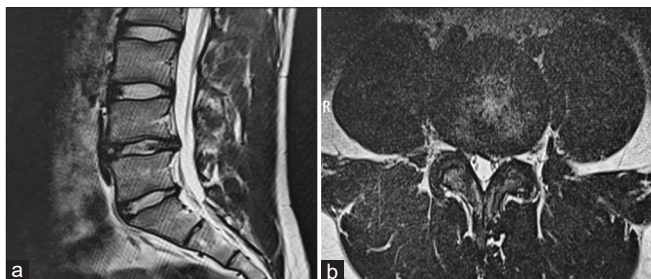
(a) Preoperative magnetic resonance imaging (MRI) spine T2-weighted images showing L4–L5 intervertebral disc protrusion, sagittal T2 image (a). (b) Preoperative MRI spine T2-weighted images showing L4–L5 intervertebral disc protrusion, axial T2, image (b).
